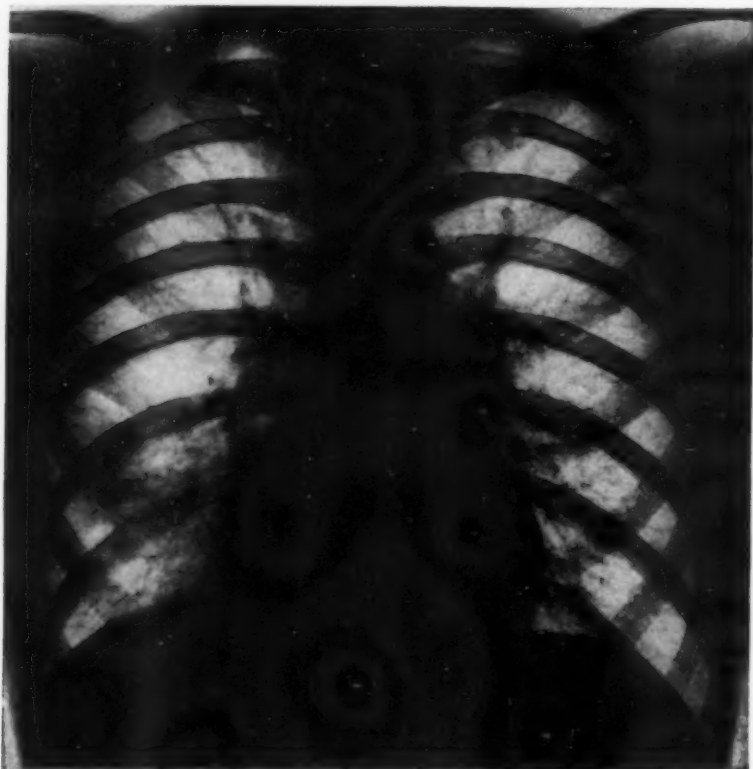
Roentgenogram (September 18). Resolution almost complete on the left, partial on the right.
